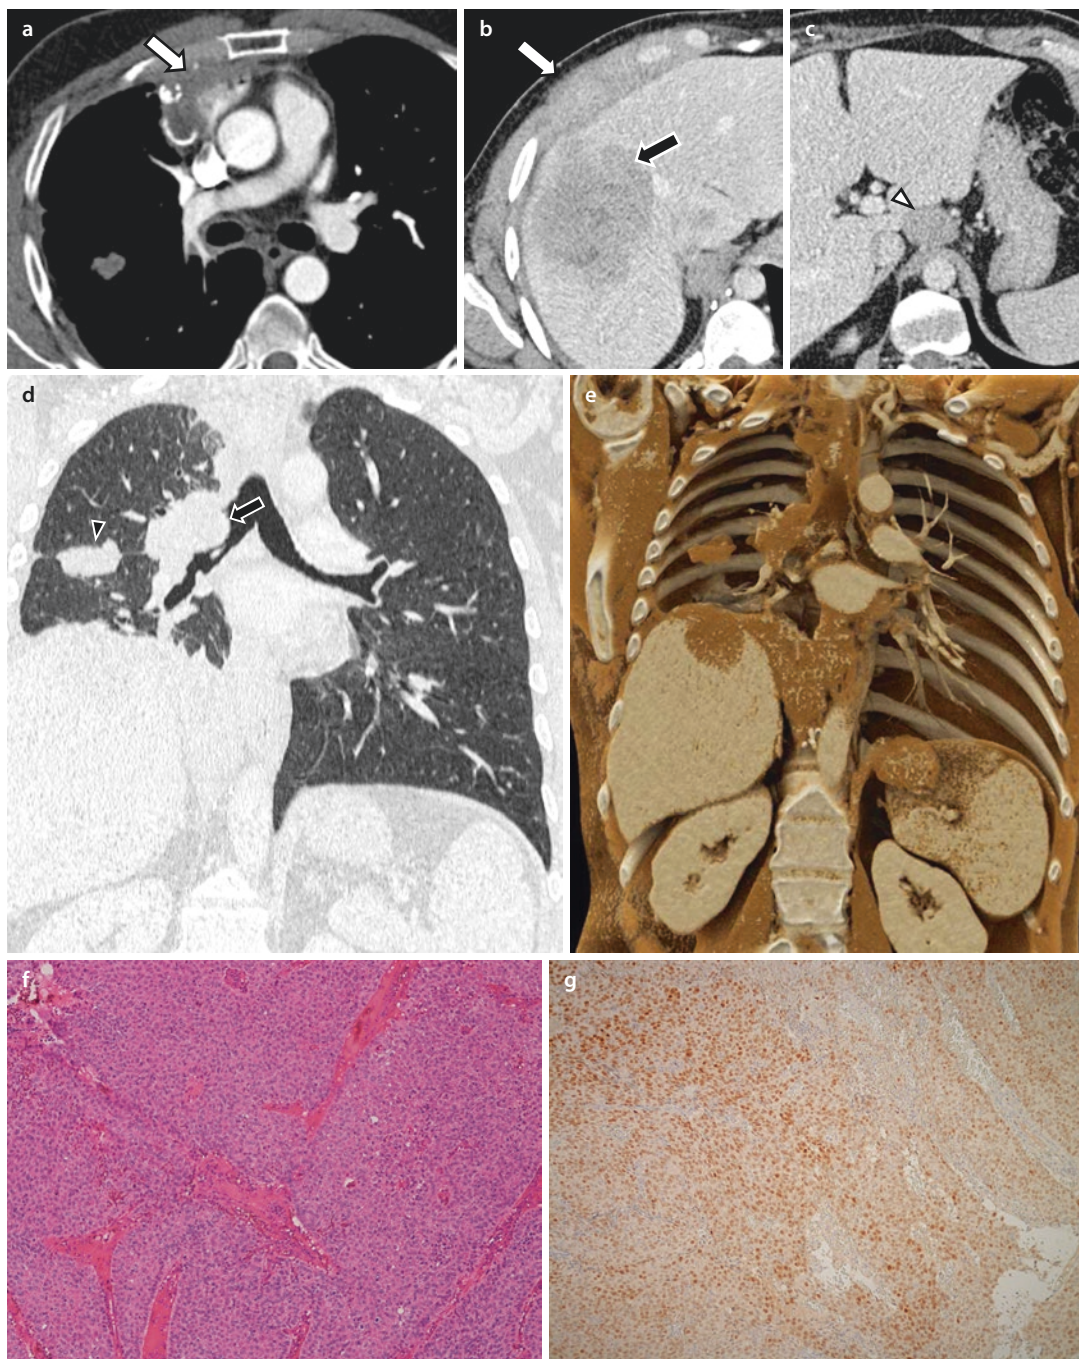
a Follow-up CT scan of a 40-year-old male patients with previous resection of a B3 thymoma. Heterogeneous partly calcified mass within prevascular compartment that does not display an adipose fat plane with adjacent structures. Various localizations were detected, including a heterogeneous liver lesion in the right lobe (black arrow in b) and a diffuse thickening of anterior thoracic wall (white arrow in b), an enlarged coeliac lymph node (white arrowhead in c). The patient suffered from respiratory symptoms caused by bronchial invasion (black arrow in d, multiplanar reformatted
